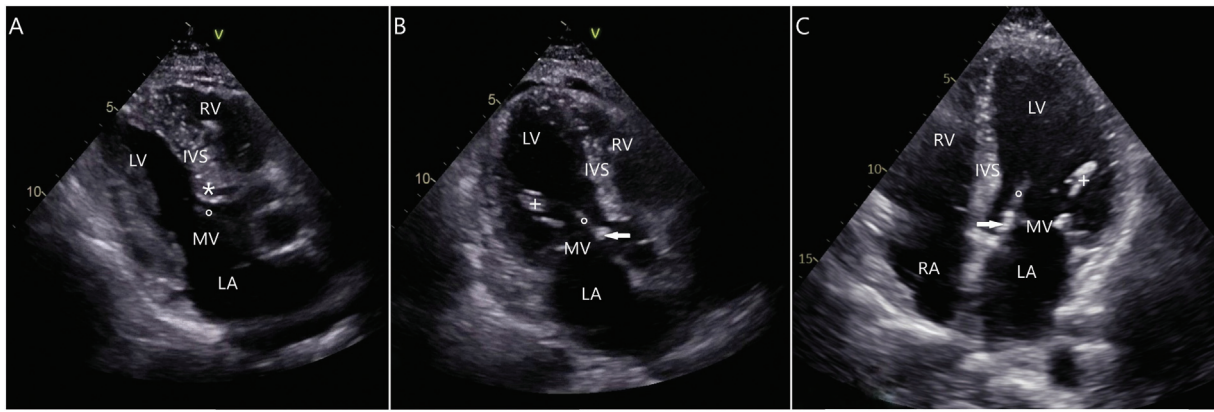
(A) Preoperative transthoracic echocardiogram showing a severe subvalvular aortic outflow tract muscular obstruction. Note the markedly hypertrophied septal “knob” (white asterisk) and its close contact with the AML (white bullet). (B) Postoperative transthoracic echocardiogram demonstrates a reduction of the thickness of the interventricular septum with reconstruction of the mitral valve by patch augmentation of the AML (white arrow) and loop insertion (white plus). (C) Transesophageal echocardiogram at 1-year follow-up showing a competent reconstructed mitral valve with normal thickness of the IVS. AML, anterior mitral leaflet; IVS, interventricular septum; LA, left atrium; LV, left ventricle; MV, mitral valve; RA, right atrium; RV, right ventricle.
